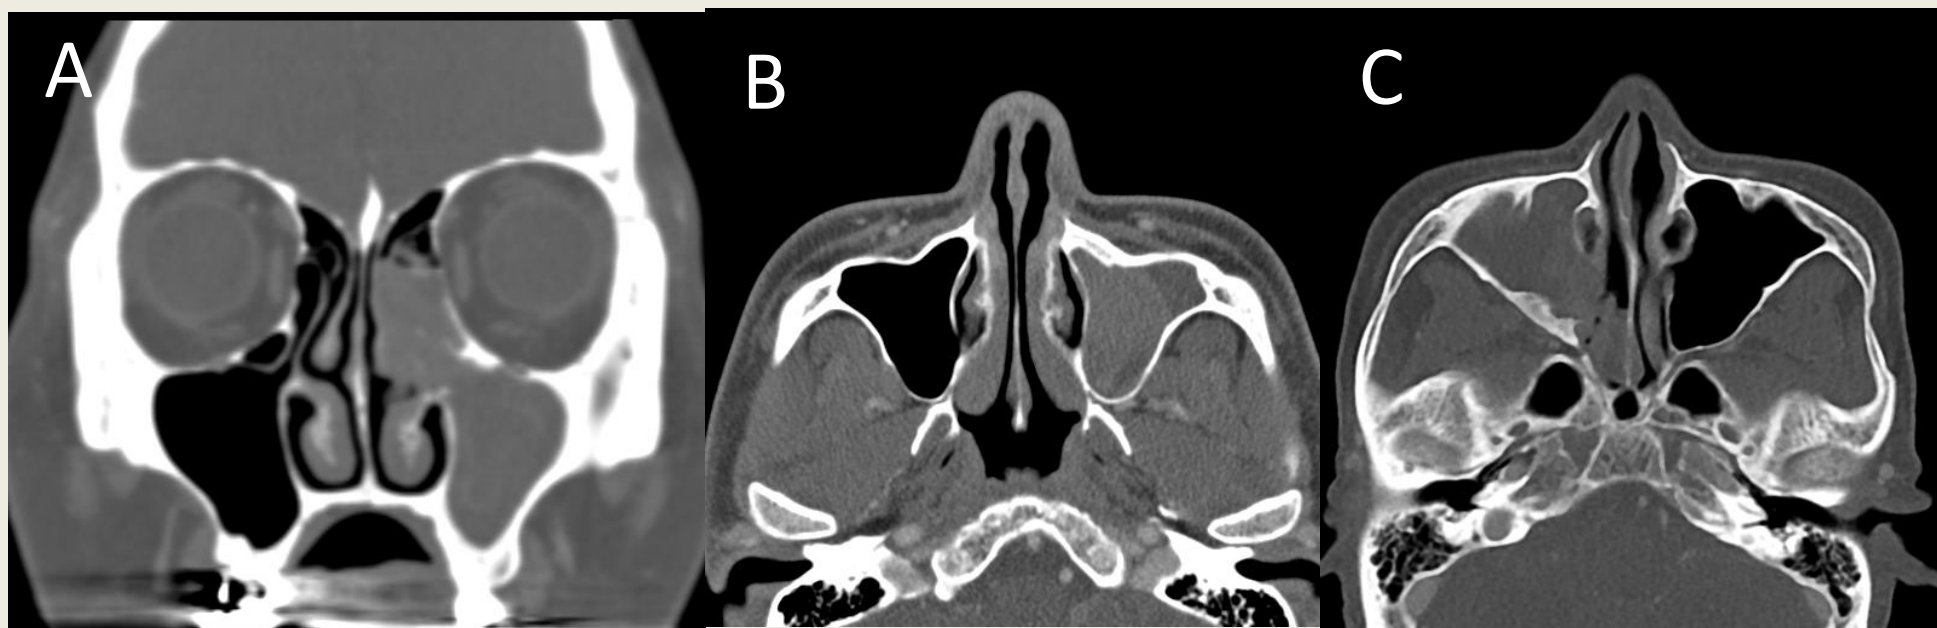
Focal hyperostosis found in the maxillary sinus inverted papilloma on the CT imaging. A, coronal CT image shows focal hyperostosis in the left superior wall of the maxillary sinus. B and C, axial CT images show diffuse hyperostotic lesion in the left anterior and the right posterior wall.
